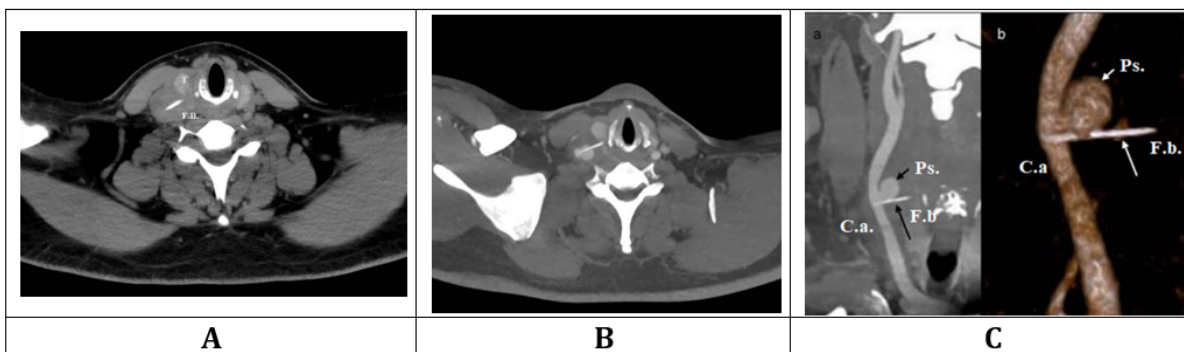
(A) Cervical computed tomography (CT) scan without contrast. Axial basal view of a CT scan (64 slices Ingenuity, Philips, Eindhoven, Netherlands) before administration of contrast medium. A 3-cm hyperdense fishbone can be observed on the right side, migrated into the soft tissues and right neck vascular bundles. Without administration of iodinate contrast medium, it was not possible to assess which vessel had been involved. Abbreviations: T: Thyroid gland; Fb.: foreign body. (B) Contrast-enhanced computed tomography: arterial and vascular phase. Axial view of a contrast-enhanced CT scan (64 slices Ingenuity, Philips, Eindhoven, Netherlands) in the arterial and vascular phases; maximum intensity projection (MIP) technique with 10 cm thickness. A 3-cm hyperdense fishbone can be observed with the lateral extremity in the common carotid artery, the medial extremity in the neck soft tissue (behind the right thyroid lobe), and the pseudoaneurysm on the medial side of the carotid artery at the point at which the fishbone enters the vessel. (C) Contrast-enhanced CT scan in the coronal plane in the arterial phase. Contrast-enhanced CT scan in the arterial, vascular phase (CT64 slices; Ingenuity, Philips) after intravenous injection of 80 ml of the nonionic soluble water Iopamiro 370 mg/ml (Bracco, Milan, Italy). A 3-cm hyperdense fish bone can be observed with the lateral extremity in the common carotid artery and the medial extremity in the neck soft tissue. A pseudoaneurysm on the medial side of the carotid artery at the point of fish bone entrance is observed. (A) A coronal view of the right carotid artery was obtained using the MIP technique with a thickness of 10 mm. (B) On the right side, the same CT arterial vascular phase scan was performed using the volume rendering (VR) technique to create a three-dimensional representation of the data. The carotid artery pseudoaneurysm and the fish bone with its medial extremity within the artery are well depicted. Fb: foreign body; Ps.: pseudoaneurysm; C.a.: common carotid artery.
